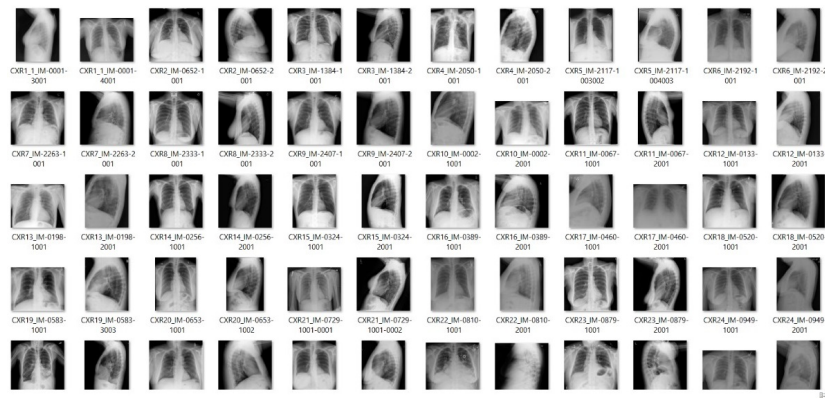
OpenI dataset Chest X-rays (frontal and lateral)
